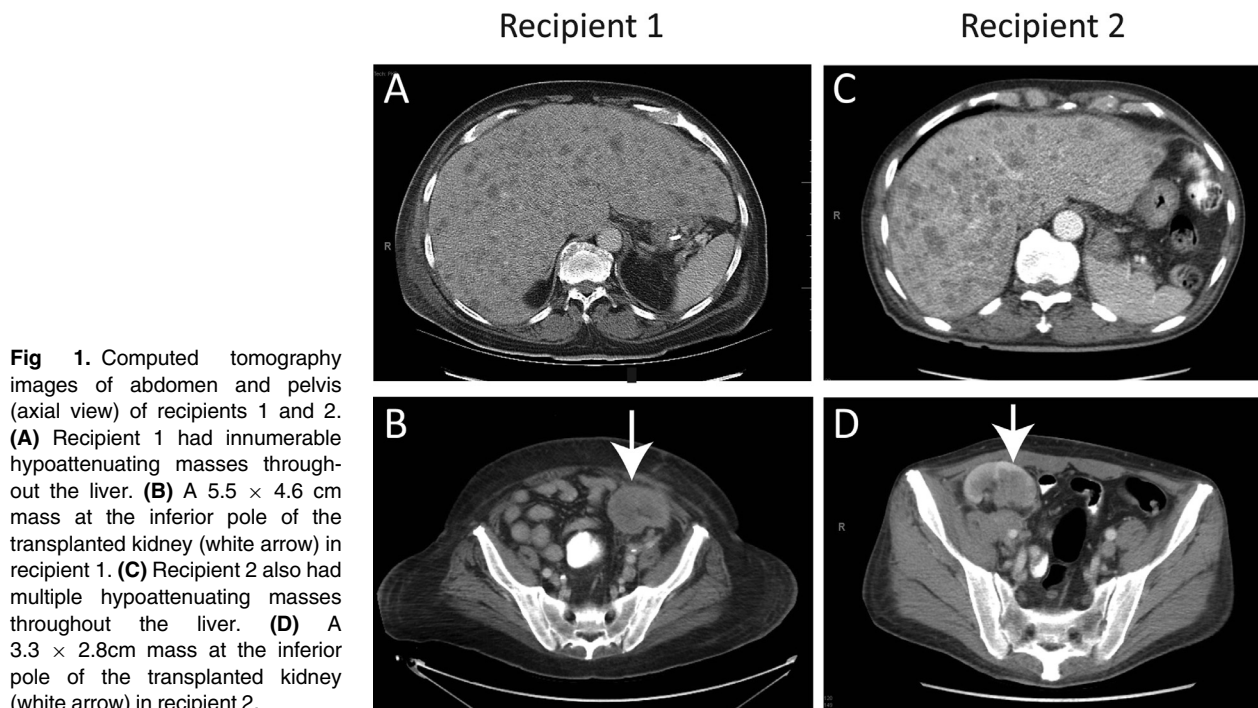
Computed tomography images of abdomen and pelvis (axial view) of recipients 1 and 2. (A) Recipient 1 had innumerable hypoattenuating masses throughout the liver. (B) A 5.5 × 4.6 cm mass at the inferior pole of the transplanted kidney (white arrow) in recipient 1. (C) Recipient 2 also had multiple hypoattenuating masses throughout the liver. (D) A 3.3 × 2.8 cm mass at the inferior pole of the transplanted kidney (white arrow) in recipient 2.
